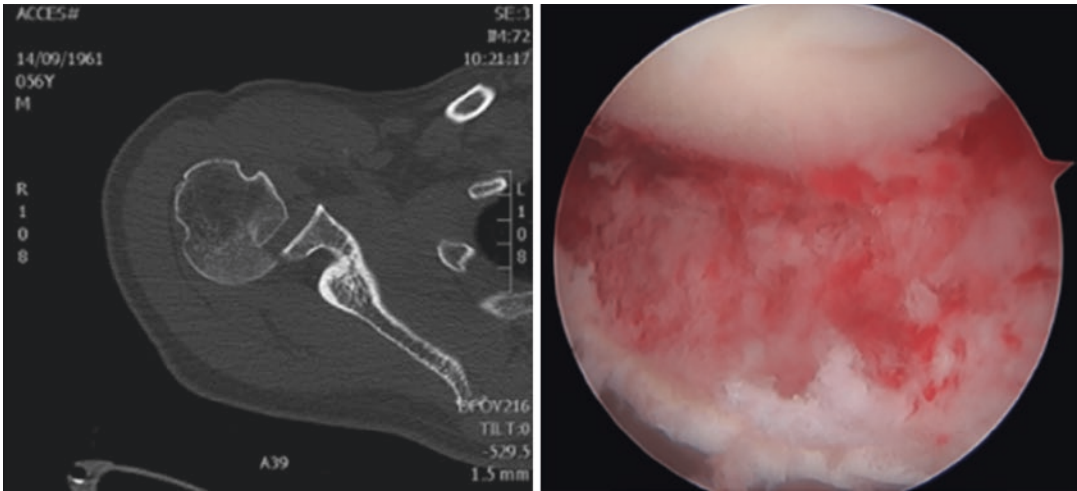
Posterior dislocation of humeral head with impact fracture of anterior articular surface. Pre-operative MRI and intra-operative arthroscopic view
